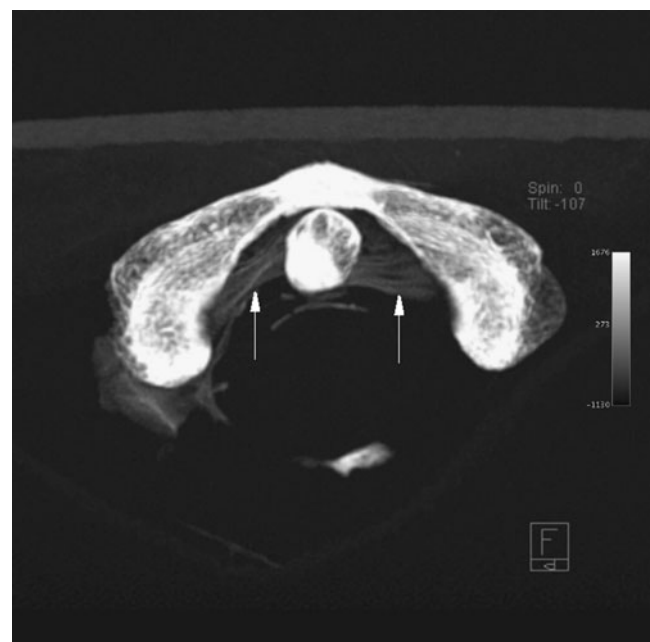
Axial CT scan of the posterior arch and the two lateral masses of the atlas embracing the dens with the intact alar ligaments (arrows)
